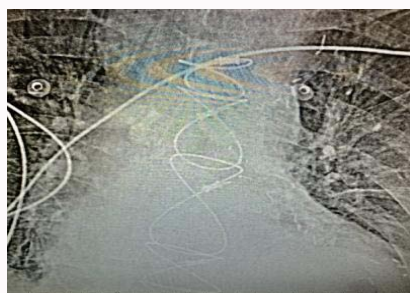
Radiograph of sternal cables.
